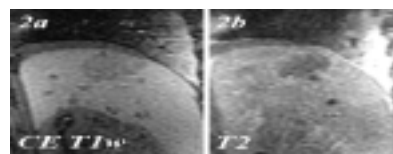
Post-ablation T1- and T2-weighted images.
